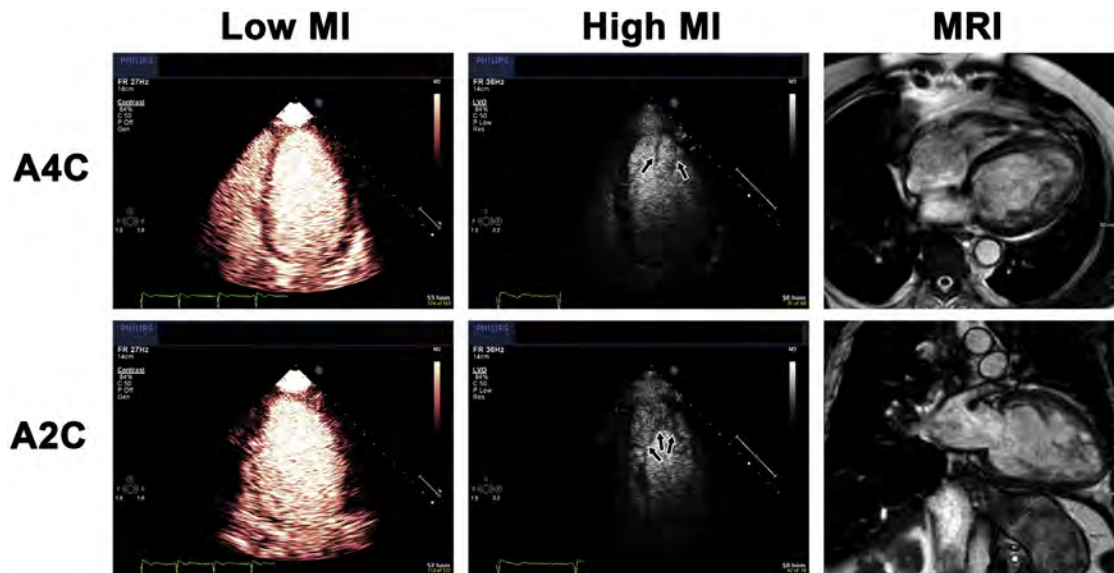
Apical four- and two-chamber (A4C and A2C) views at end-diastole in a patient with unexplained cardiomyopathy. VLMI imaging demonstrated LV cavity and myocardial opacification, but real-time B-mode harmonic imaging at a slightly higher MI (*middle*) resulted in destruction of trabecular myocardial microbubbles and better delineation of the noncompacted layer (*arrows*). The noncompaction thickness in this intermediate-MI real-time harmonic imaging mode correlated closely with that seen at magnetic resonance imaging (*right*).
